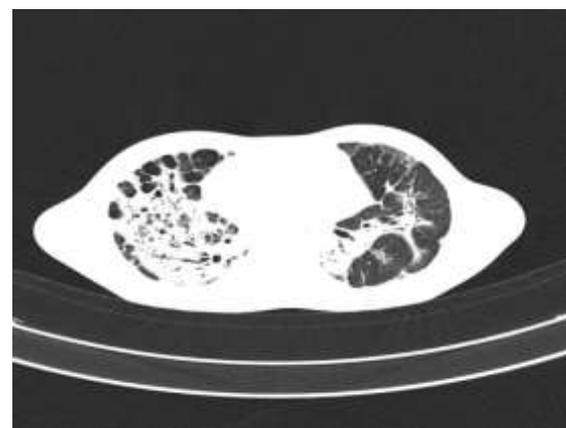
HRCT Chest: Ground glass opacities with consolidation noted in bilateral lower lobes
